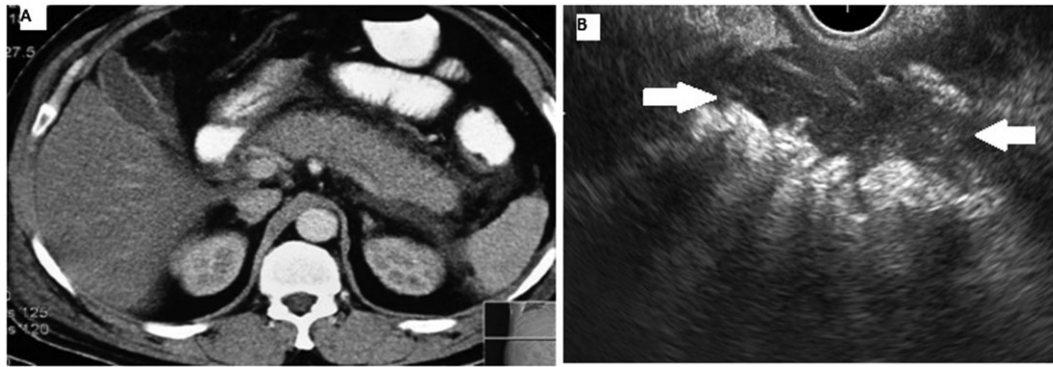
(a) Contrast enhanced computed tomographic scan showing extra-pancreatic necrosis and (b) endoscopic ultrasound showing heterogeneous echotextured peri-pancreatic area suggestive of extra-pancreatic necrosis (arrow).
